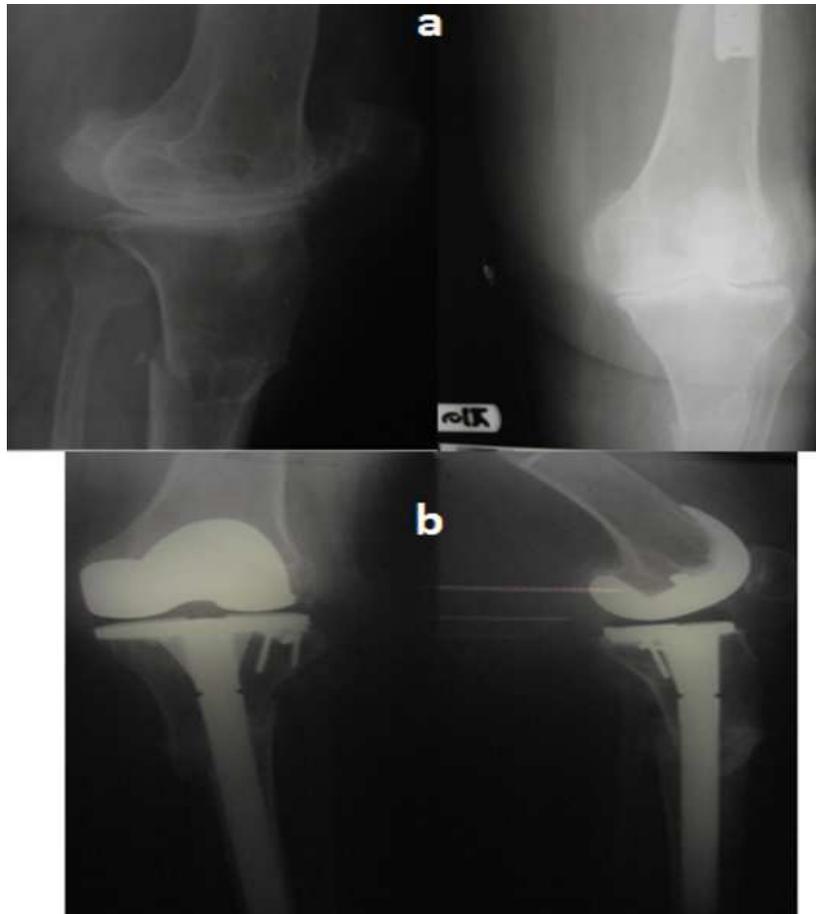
A 67 years old male suffered from proximal tibial fracture AO type A treated with TKA. a) Preoperative anteroposterior and lateral x-rays and b) Anteroposterior and lateral x-rays taken 4 years Postoperatively.
